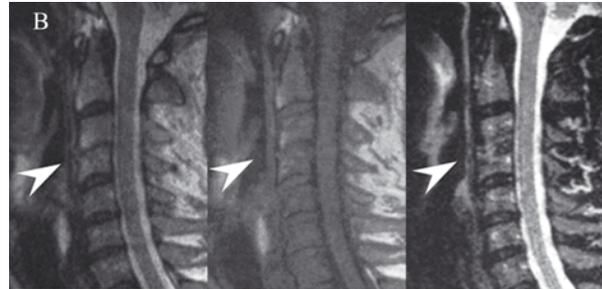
Case 2: A sagittal T1, T2-weighted and TIRM magnetic resonance images at the beginning of antituberculous treatment.
